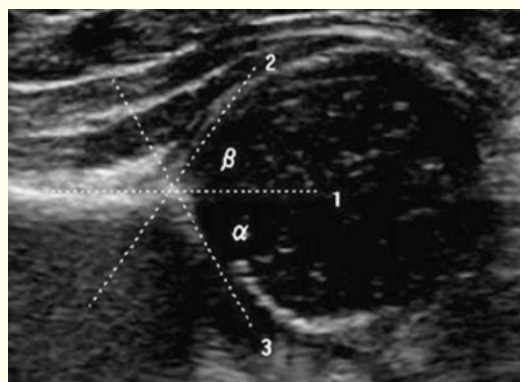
Ultrasound Alpha and Beta angles.
